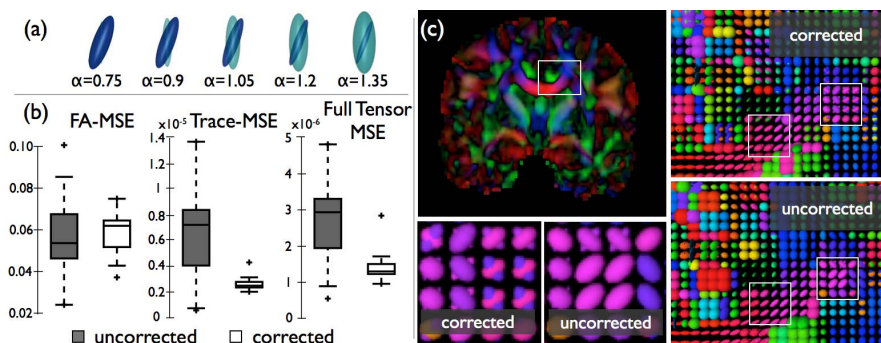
(a) Different multi-fascicle models would generate the same DWI signals at a single b-value. Examples are given for different values of  $\alpha$ . (b) Mean squared errors of the tensor trace and full tensor show a significant advantage of the corrected multi-tensor models over the uncorrected ones. (c) Due to the uncertainty in the parameter  $\alpha$ , some multi-tensor models will have one component with inflated eigenvalues and one component with much lower eigenvalues (see eq. [1]) potentially occluded by the first one. Areas that are well represented by a single-fascicle (such as the corpus callosum) are not affected.
